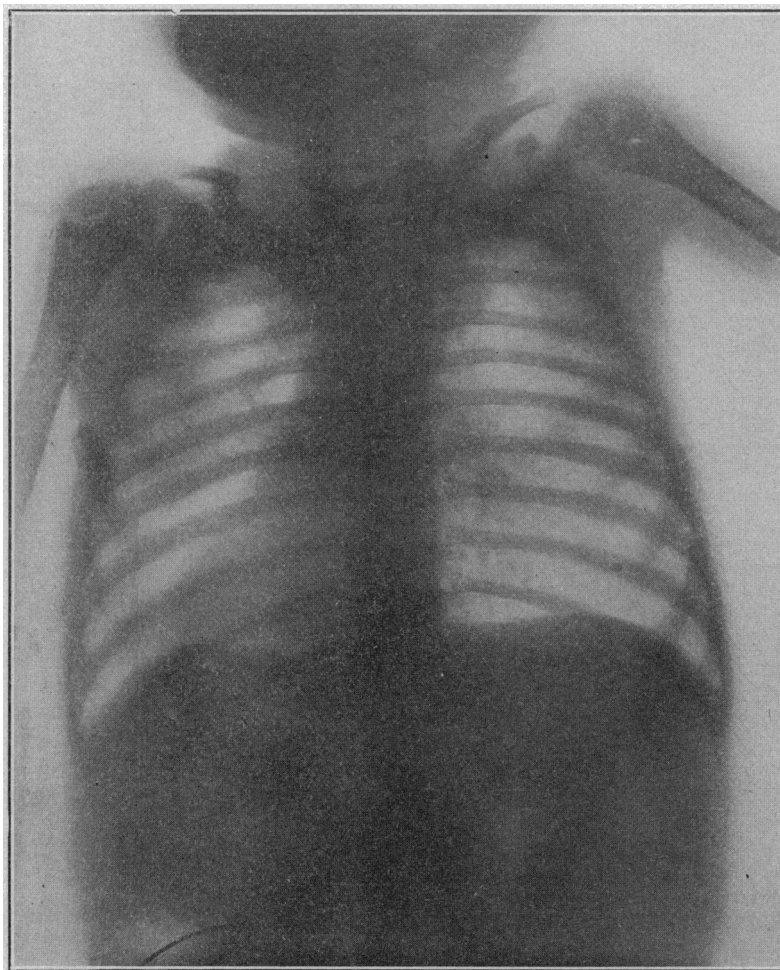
Radiograph showing enlarged thymus gland.
